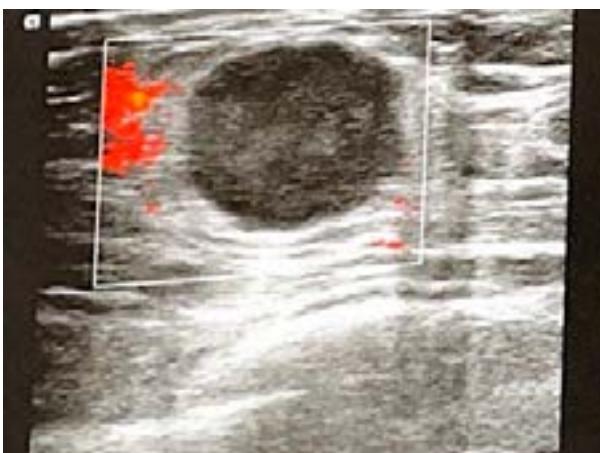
Right breast ultrasound (September 2023)
